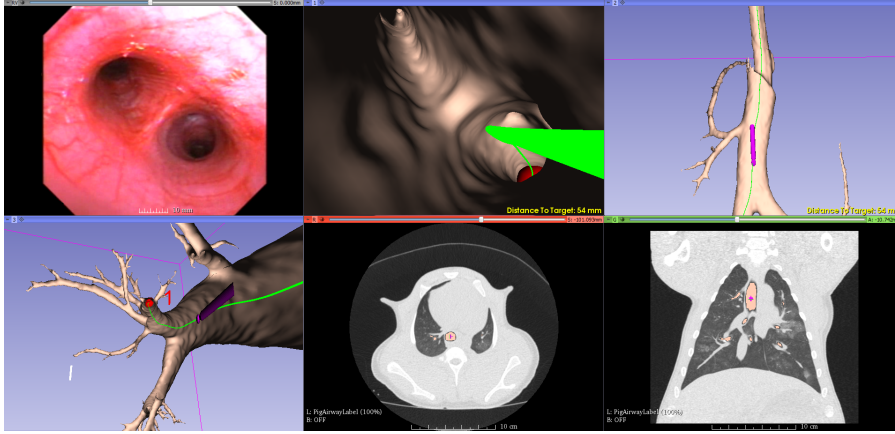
Visualization area of the system when a third 3D view is selected by the user. The sagittal CT view is suppressed, the axial view is shifted to the right, and the third 3D view is placed on the initial axial view position. The third 3D view shows the airway model, the probe (purple), and the paths from a proximal perspective. This may be helpful in cases where branches seem to overlap in other views.
